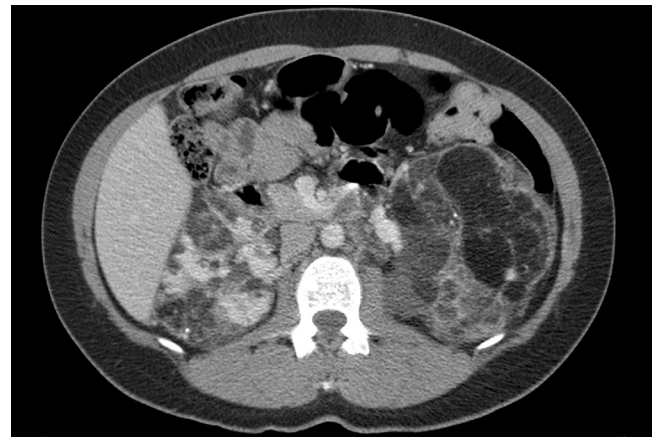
■ Multifocal angiomyolipoma of the kidneys. CT of the kidneys demonstrates extensive infiltration of both kidneys with multiple fat-containing lesions in a patient with tuberous sclerosis. Angiography should be considered in patients with such large tumours with a view to prophylactic embolisation as the risk of bleeding is high.
